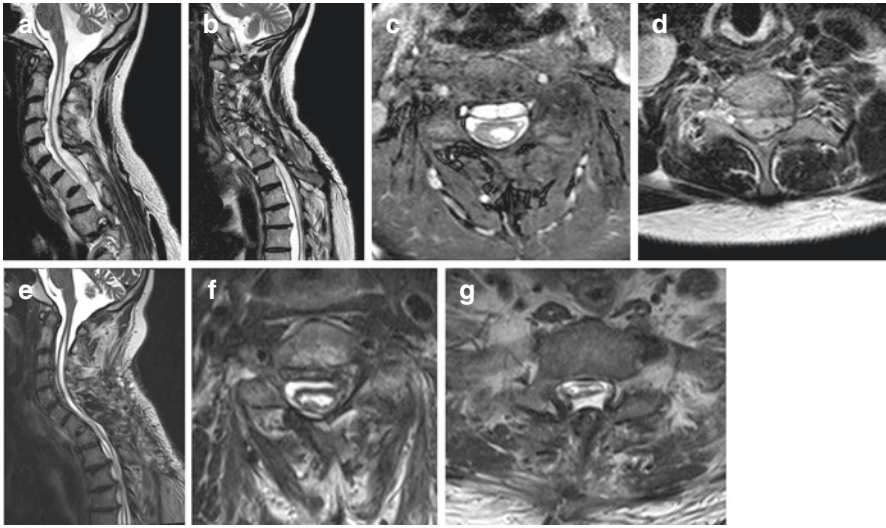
(a) This T2-weighted MRI scan of a 53-year-old man shows a posttraumatic syrinx C2–Th5 related to a spinal injury at C7/Th1, which had resulted in an incomplete spinal cord injury 18 years earlier. The syrinx was caused by arachnoid scarring at the injury level combined with a narrowing of the subarachnoid space due to a posttraumatic dura dissection between inner and outer layer of the dura anteriorly from C2 down the entire thoracic spine (b). (c) This axial scan at C6 shows the syrinx in the posterior left of the cord. The dissection is caused by a rupture of the inner dural layer in the root sleeve C6/7 on the left side (d). At surgery, the CSF passage was established at the cervicothoracic junction, and the dura defect in the root sleeve was closed with muscle and fibrin glue. Postoperatively, the sagittal T2-weighted MRI demonstrates a reduction of the syrinx as well as the dura dissection (e). The axial scans at C6/7 (f) show fibrin glue in the left root sleeve and the dissection anteriorly as well as the duraplasty and free CSF space at Th1 (g)
